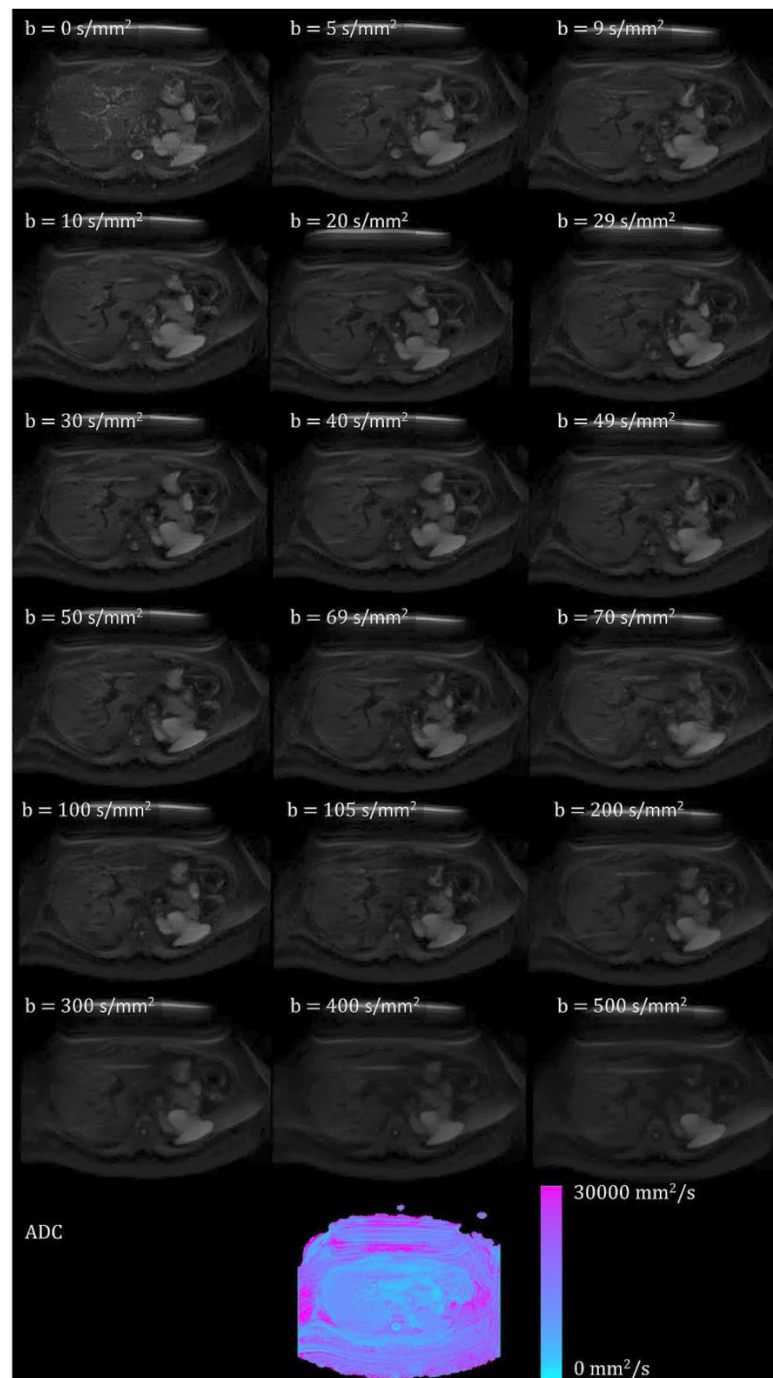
Images produced from the DWI sequence. Respective b-values are displayed in the top left corner of each image. The corresponding ADC map is shown on the bottom row.
